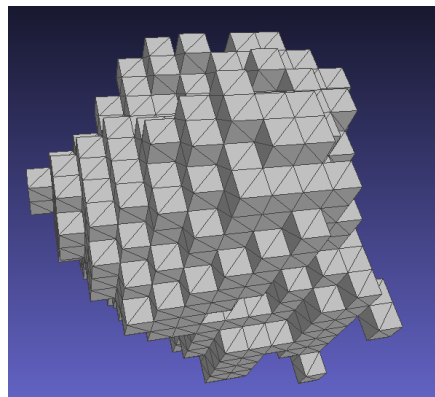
STL of the segmented tumor from MRI 05 using *Meshlab*.
